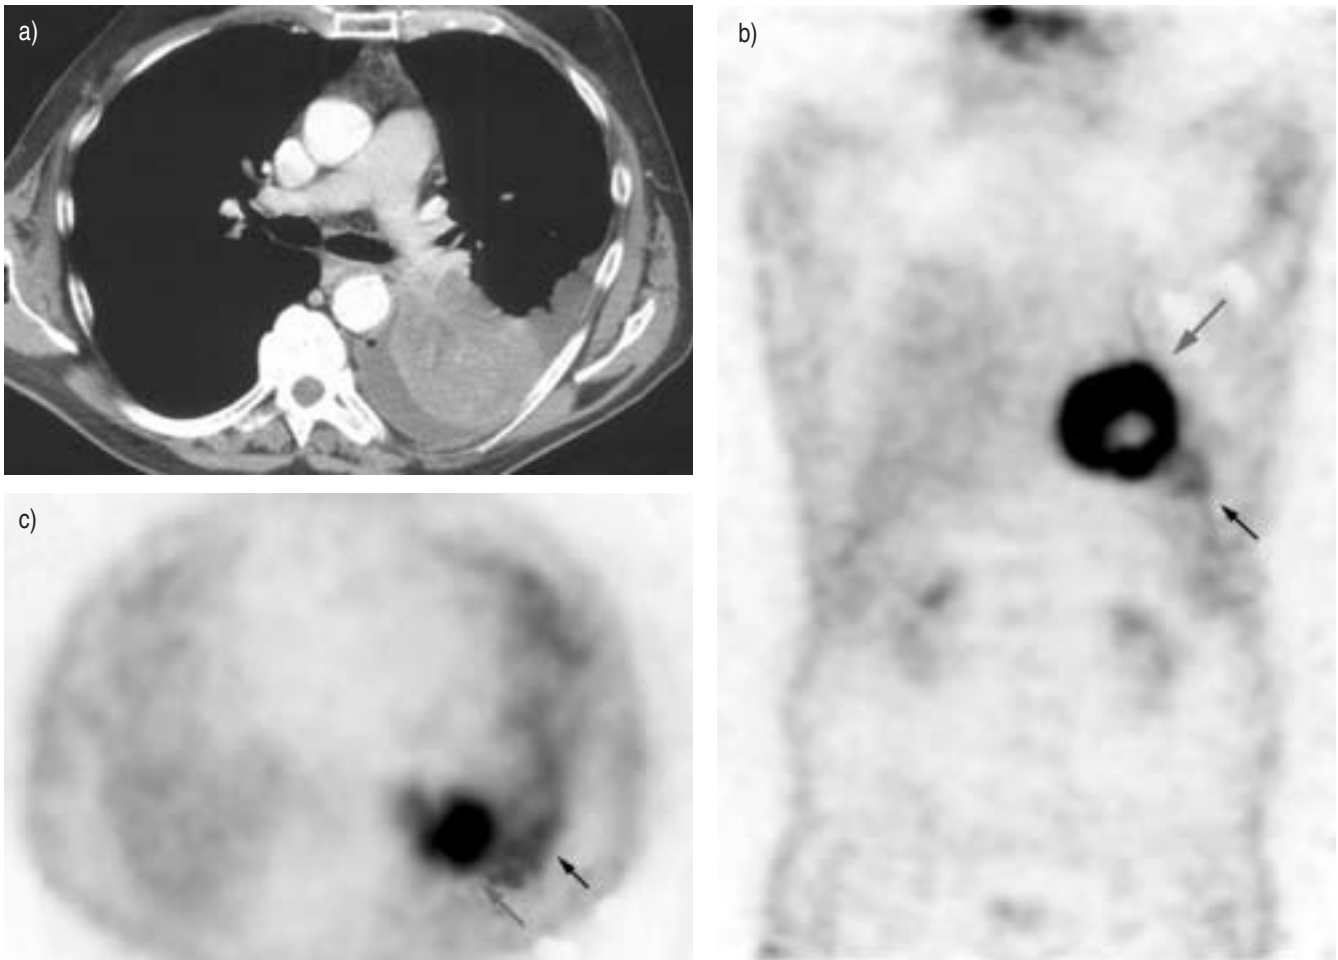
A 59-yr-old patient with pleural effusion. a) Computed tomography scan showed a left pleural effusion with primary lung cancer adjacent to the mediastinum. b) Three-dimensional imaging in maximum pixel raytrace in the anterior view confirmed lung tumour (grey arrow) and pleural involvement (arrow). c) Transverse ¹⁸F-fluorodeoxyglucose (¹⁸FDG) imaging *via* coincidence detection emission tomography revealed ¹⁸FDG hypermetabolism in the lung tumour with central necrosis photopenic area (grey arrow). In addition, there was a distinct focus on increased uptake in the posterior parietal pleura suggesting adjacent involvement (arrow).
